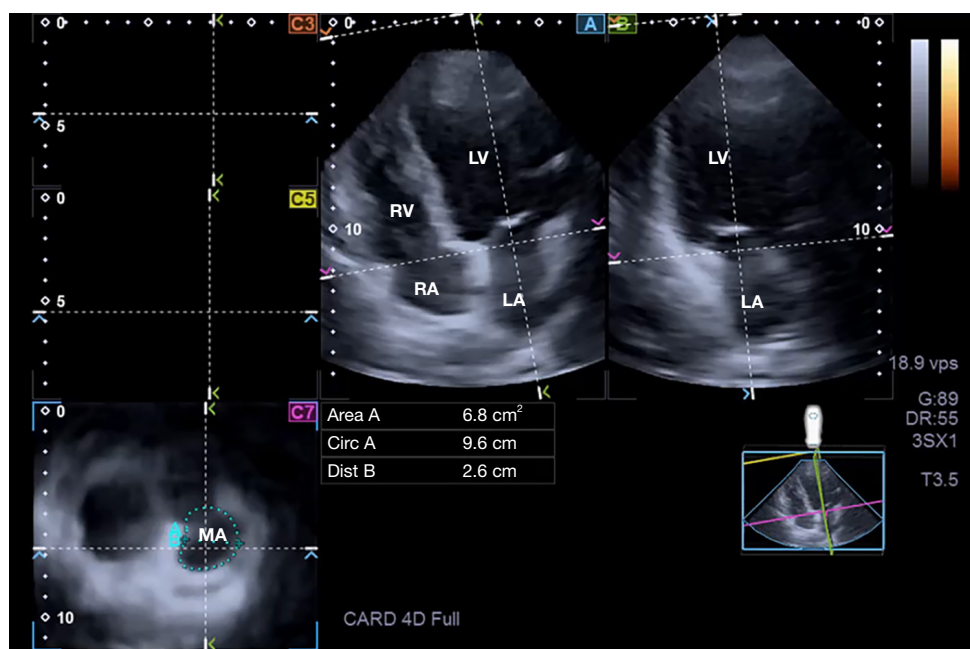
Three-dimensional speckle-tracking echocardiographic measurement of the mitral annulus: apical four-chamber (A) and two-chamber (B) long-axis views and cross-sectional view (C7) of the mitral annulus optimised on (A) and (B) long-axis views. Area, mitral annular area; Circ, mitral annular perimeter; Dist, mitral annular diameter; LA, left atrium; LV, left ventricle; MA, mitral annulus; RA, right atrium; RV, right ventricle.
